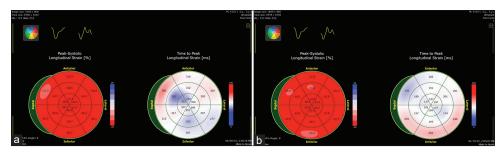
(a and b) Bull's eye depicting the relative motility of the different left ventricular segments as assessed by speckle-tracking echocardiography in patient 1 during the preoperative echocardiographic assessment (a) and the postoperative echocardiographic assessment (b)
